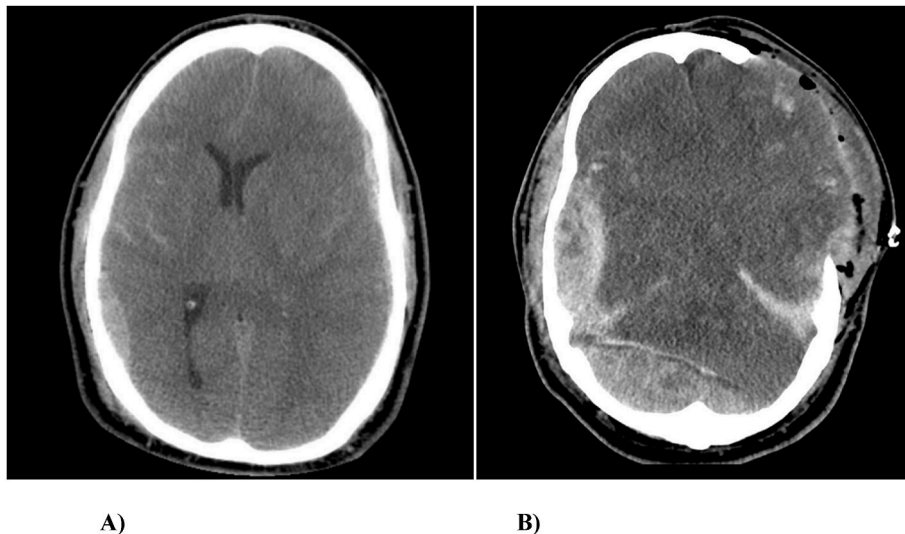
(A and B) A 38-year-old male presented in coma with a GCS score of 7. CT head revealed an acute left hemispheric subdural hematoma (SDH) along with a small right posterior temporal epidural hematoma (EDH). Patient underwent an emergent left craniectomy and evacuation of the SDH. During this procedure a massive herniation of brain through the cranial defect was noticed. B) An immediate post operative repeat CT revealed a massive expansion of the right EDH with severe infratentorial extension and brain compression. The patient died shortly after from this EDH.
